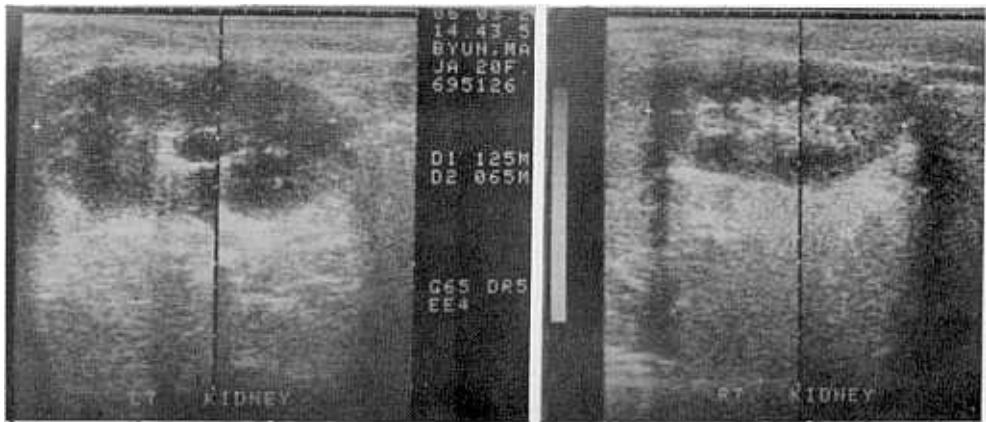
Ultrasonogram reveals an enlarged left kidney with dilatation of the renal pelvis and calyceal systems which is suggestive of hydronephrosis.
